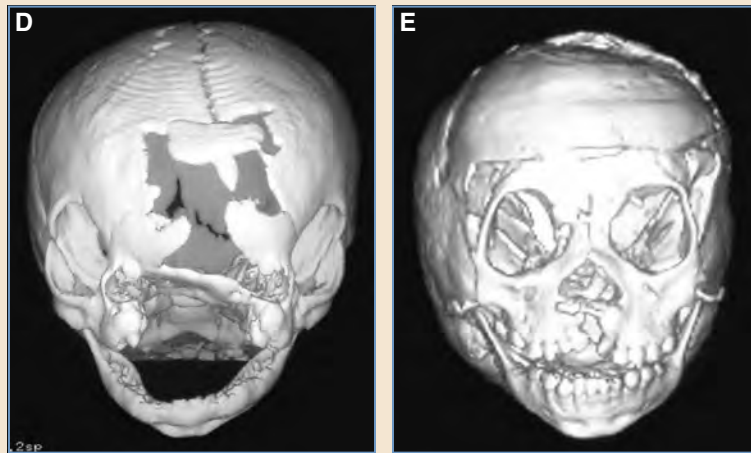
cont'd D and E, Preoperative and postoperative three-dimensional CT scans.
